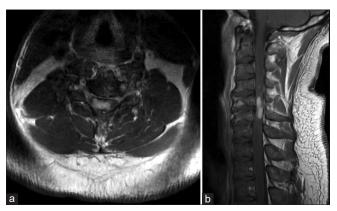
(a) Preop axial T1-weighted magnetic resonance imaging (MRI) of the cervical spine at C5. (b) Preop sagittal T1 weighted MRI of the cervical spine with an enhanced intramedullary spinal cord lesion from C4 to C6.
